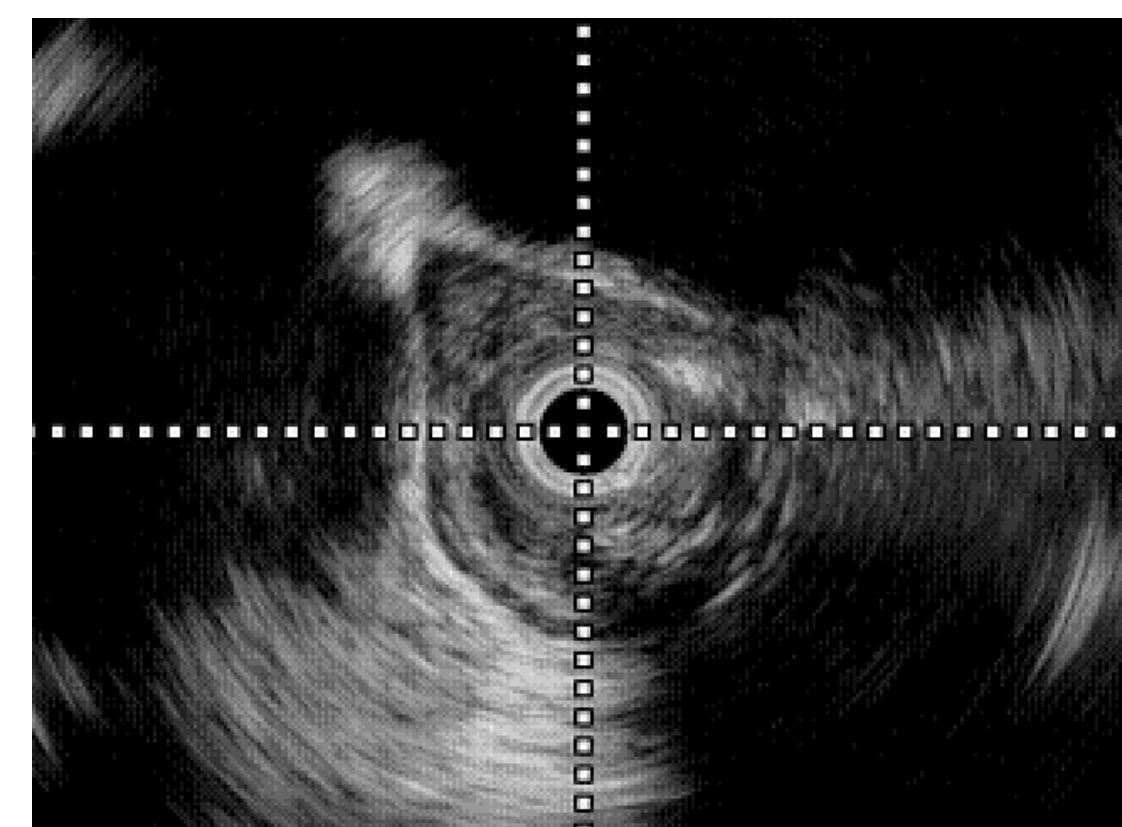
Ultrasound Image of Esophagus* at maximum CSA. Luminal CSA was traced to compare with impedance-derived CSA
